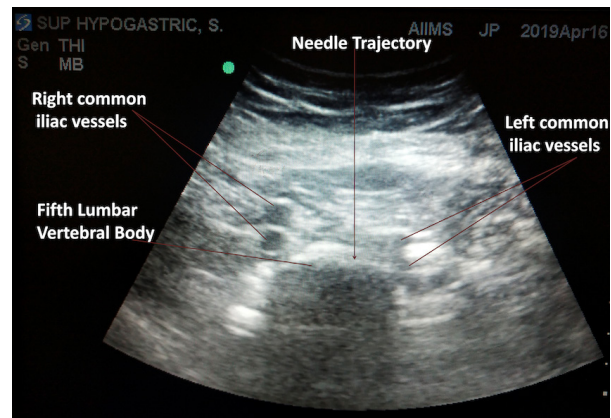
Transverse ultrasound image showing the body of the fifth lumbar vertebra along with the common iliac vessels and needle trajectory out-of-plane.
